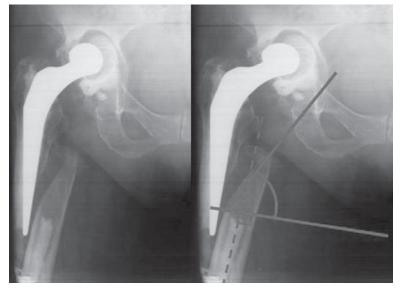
X-ray images of total hip showing the methodology of fracture angle measurement. The fracture angle is calculated on the basis of an initial line drawn perpendicular to the long axis of the bone. (Reproduced with permission from Elsevier, [25].)
